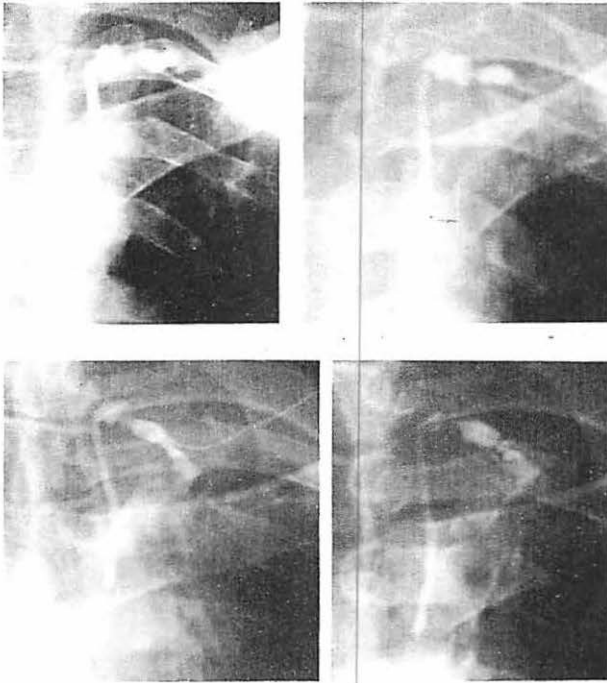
Radiographic appearance of the terminal thoracic duct (J.A.).
